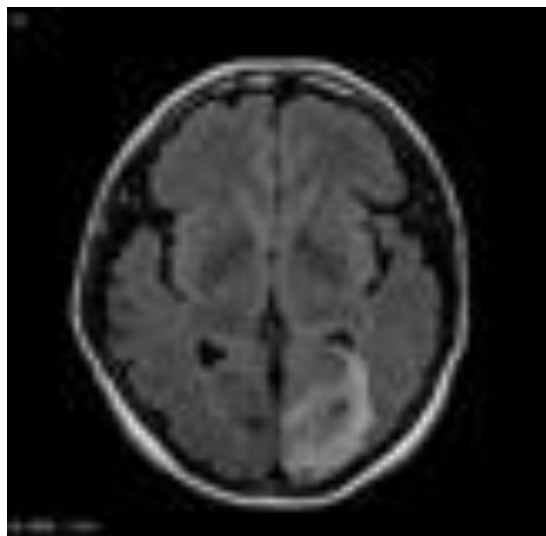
Metastatic tumor from lung cancer in left occipital lobe. on DWI show low signal surrounding by high signal edema.
